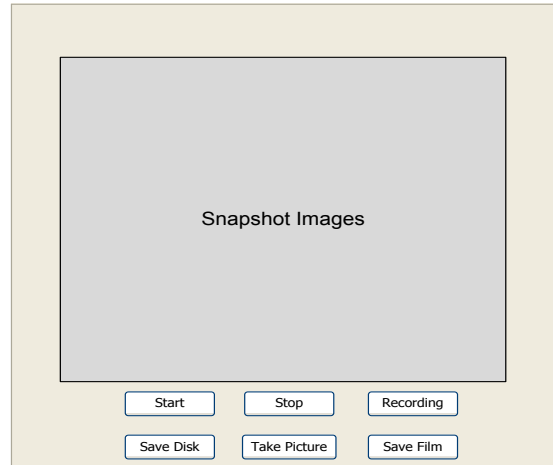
MRI Camera Interface
